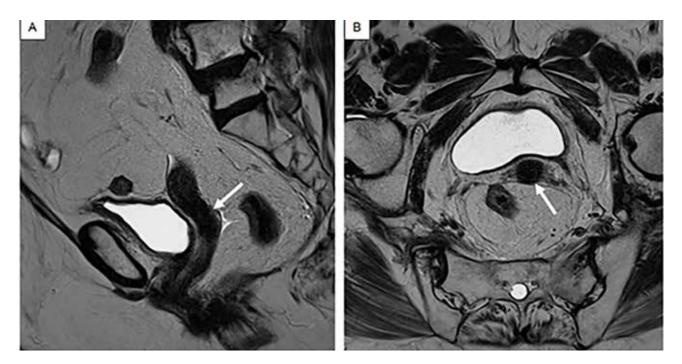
Pelvic MRI, T2W/TSE sequence, lateral (A) and axial (B) planes. Changes after chemoradiotherapy are visible. Cervix uteri are small in size, homogeneous; no unusual SI lesions are observed (arrows).
